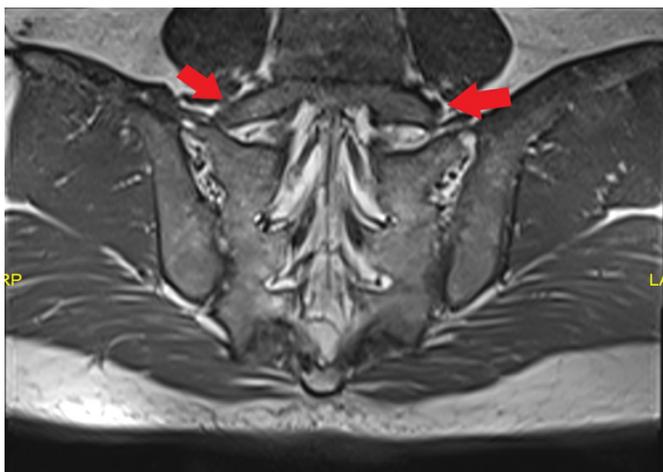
Coronal T2- weighted MRI image shows bilateral enlarged transverse processes (Type 1b)
